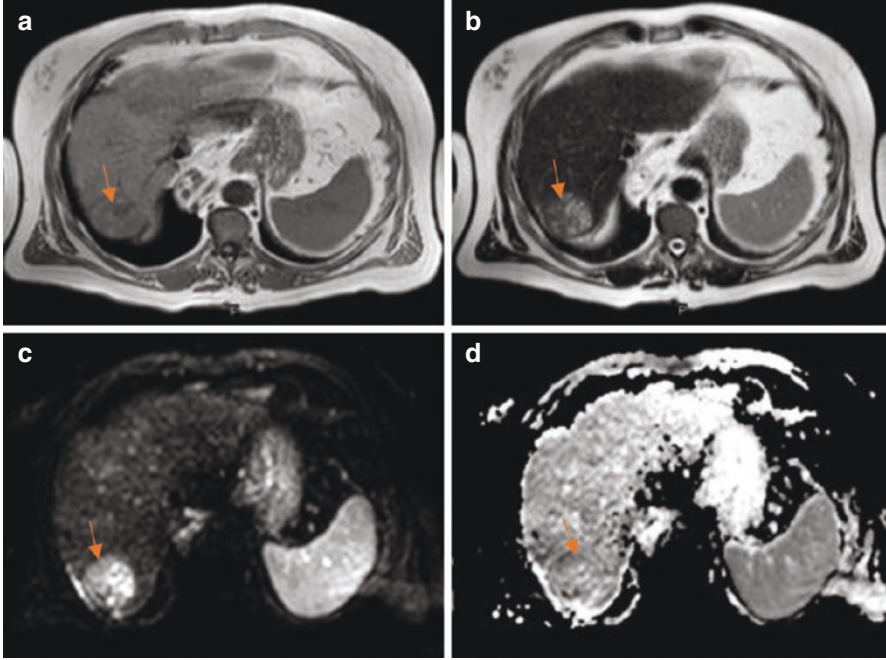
(a) Axial T1-weighted sequence showing an iso-hypointense well-defined lesion with a capsule and a central low signal area. (b) Axial T2-weighted sequence shows the internal heterogeneity of the lesion which has areas of low to intermediate signal intensity. (c and d) Diffusion-weighted and corresponding ADC map showing a high signal on the diffusion-weighted sequence with a corresponding low signal on the ADC map indicative of restricted diffusion within the lesion and characteristics in keeping with a HCC
